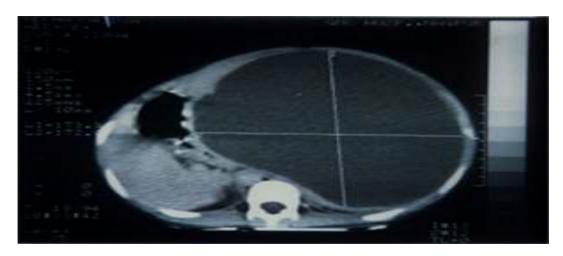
2 – CT Scan Abdomen Showing Grossly Enlarged Spleen Compressing Stomach
